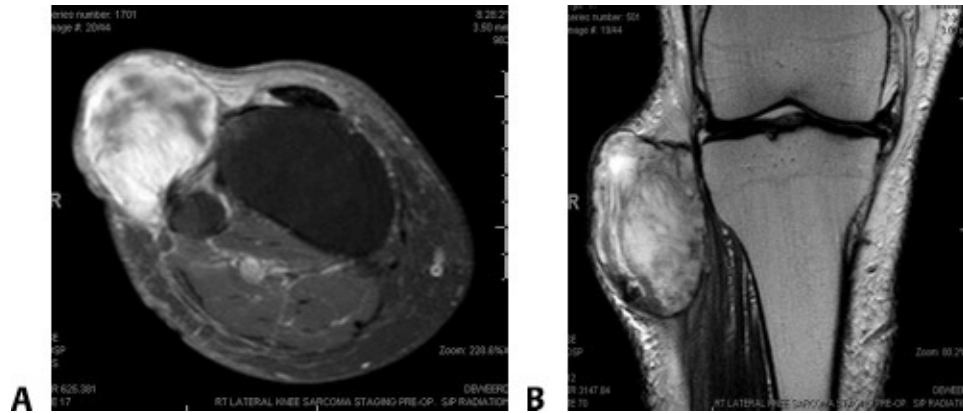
• A. Axial MRI of the thigh demonstrating a subcutaneous sarcoma. B. Coronal MRI of the thigh showing a subcutaneous sarcoma.
